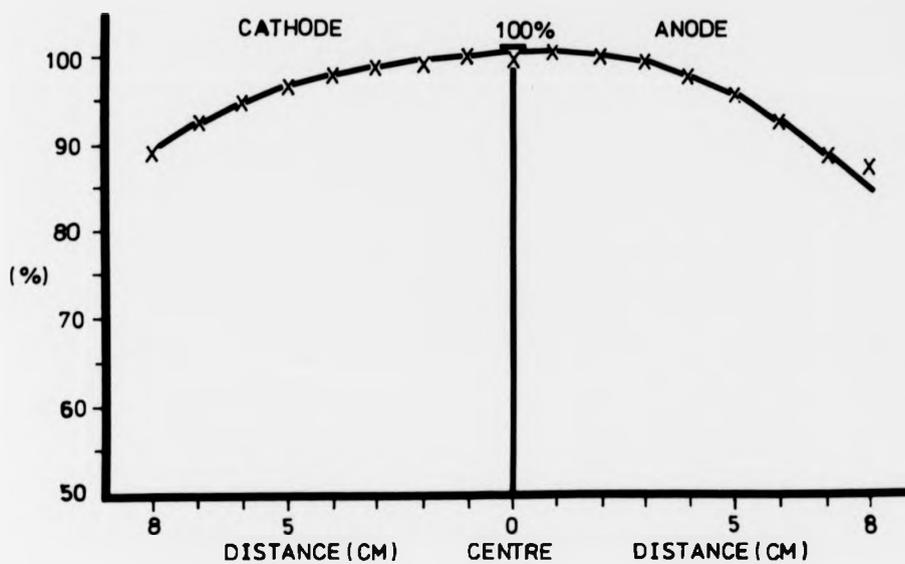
Dose distribution profile at f.s.d. 35 cm using PANTAK x-ray unit.
